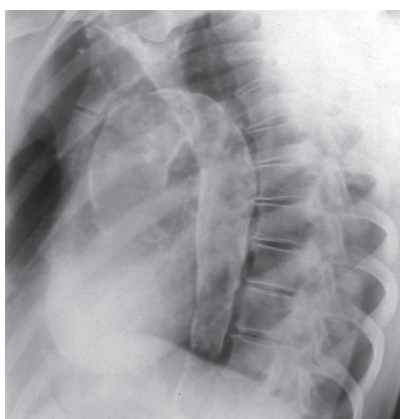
X-ray in oblique lateral view. Calcification of the walls of the thoracic aorta along its entire length
